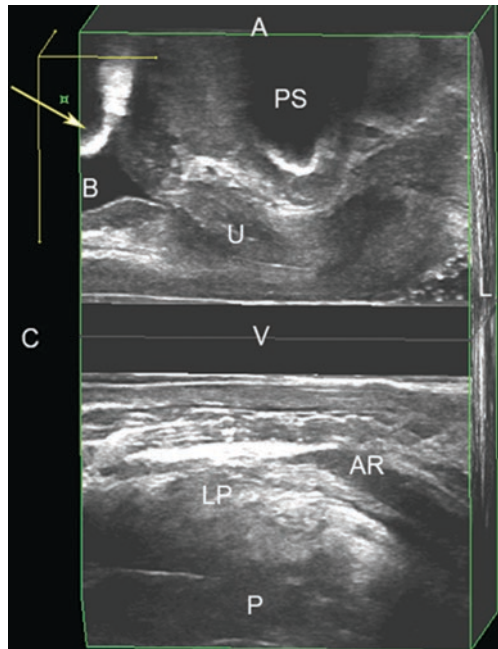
360° 3D endovaginal ultrasound image in sagittal plane showing the sling mesh (yellow arrow) in the bladder (B). Vagina (V), pubic symphysis (P), external anal sphincter (EAS), anorectum (AR), levator plate (LP), anterior (A), posterior (P), cephalad (C), left (L). (© Shobeiri)
